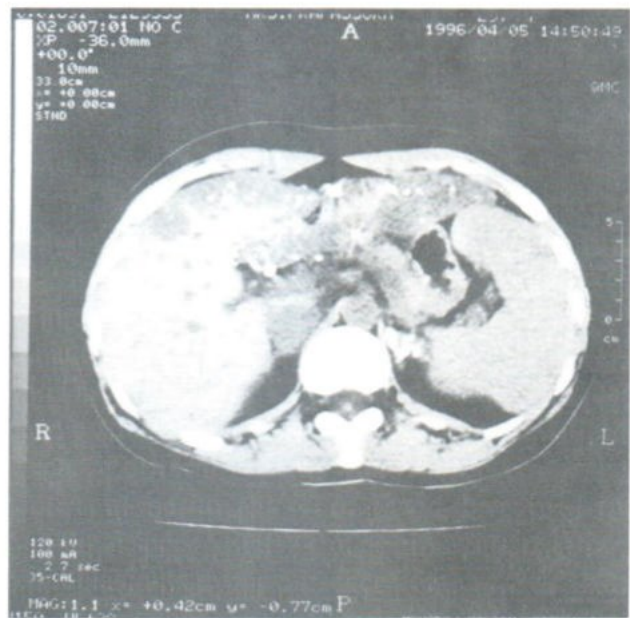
Precontrast CT scan shows multiple calcifications in the left adrenal region and multiple hypodense masses in the liver with calcifications.
